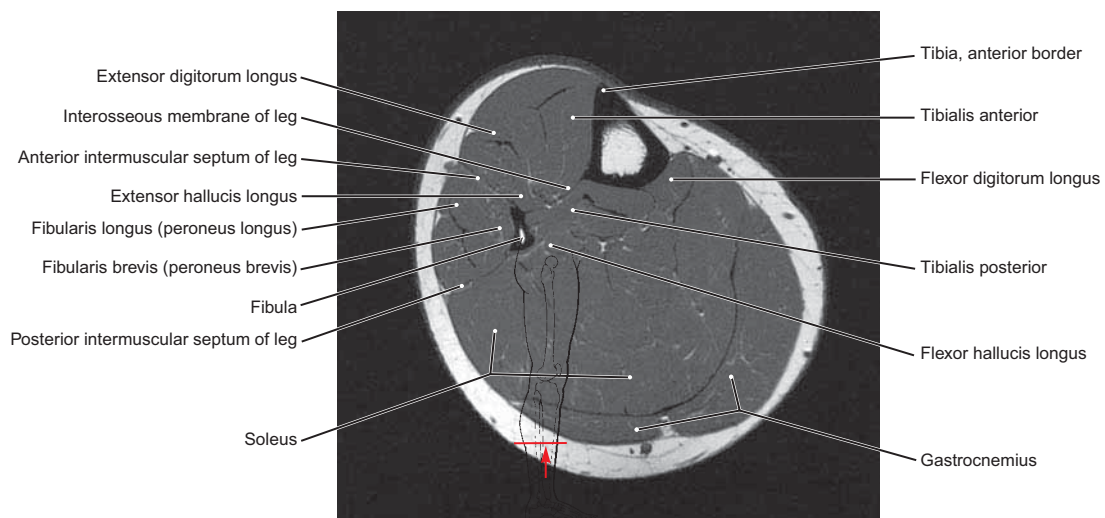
MRI: Cross Section through the Middle of the Right Leg
